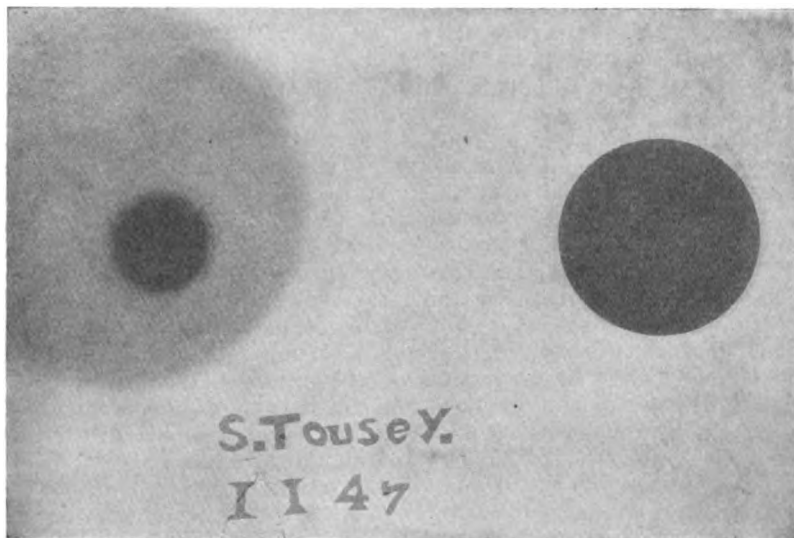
Radiographs of dollar and penny, showing secondary rays: A, Dollar 5 inches from anticathode, its shadow very faint because secondary rays from the x-ray tube reach the space behind it and show a clear image of the penny, which is close to the plate; B, dollar close to the plate and casting a dense shadow in which the penny cannot be seen. A and B made at the same exposure.
